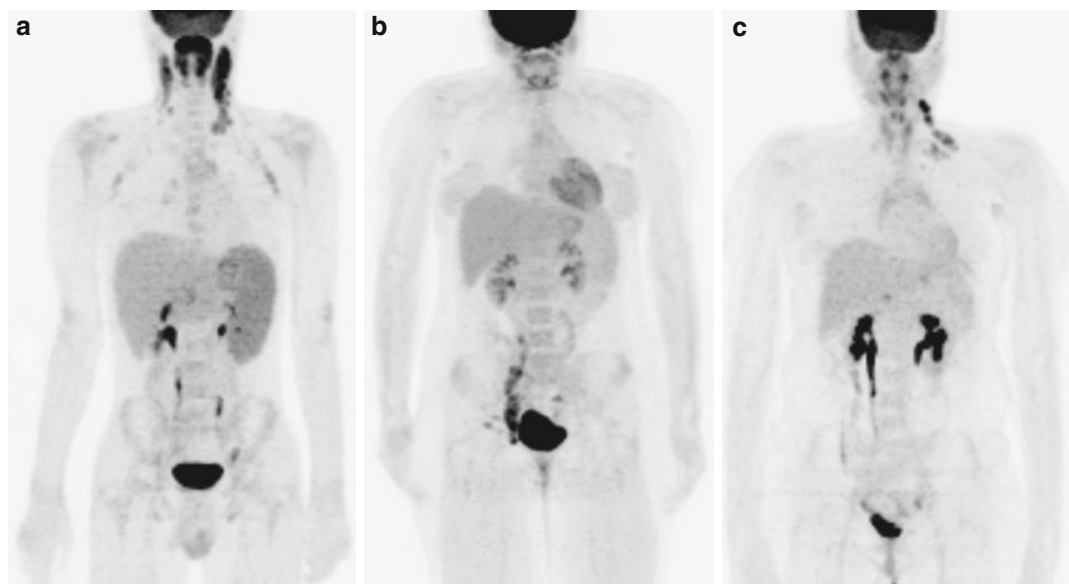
^{18}F -FDG PET in patients with non-neoplastic syndromes of lymphadenopathy. (a) A 16-year-old boy presented with fatigue, afebrile drenching night sweats, and increasing cervical lymphadenopathy. Initial viral titers were negative. A MIP of an ^{18}F -FDG PET demonstrates intense uptake in the tonsils and in cervical and supraclavicular lymph nodes and diffusely increased uptake in the enlarged spleen. Lymph node biopsy and repeat viral titers were consistent with EBV mononucleosis. (b) A 14-year-old female had a hip MRI for evaluation of pain and was found to have an incidental finding of extensive pelvic lymphadenopathy. ^{18}F -FDG PET/CT was
